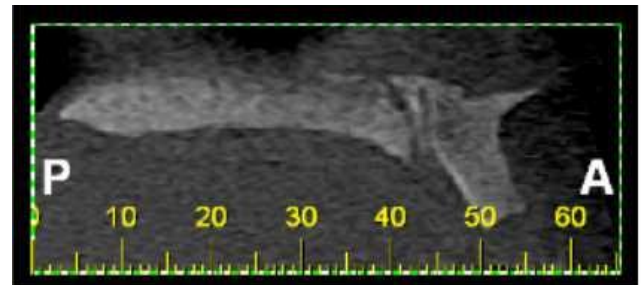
Right sagittal CBCT section showing two nasopalatine canals extending from the nasal opening to the incisive foramen.
